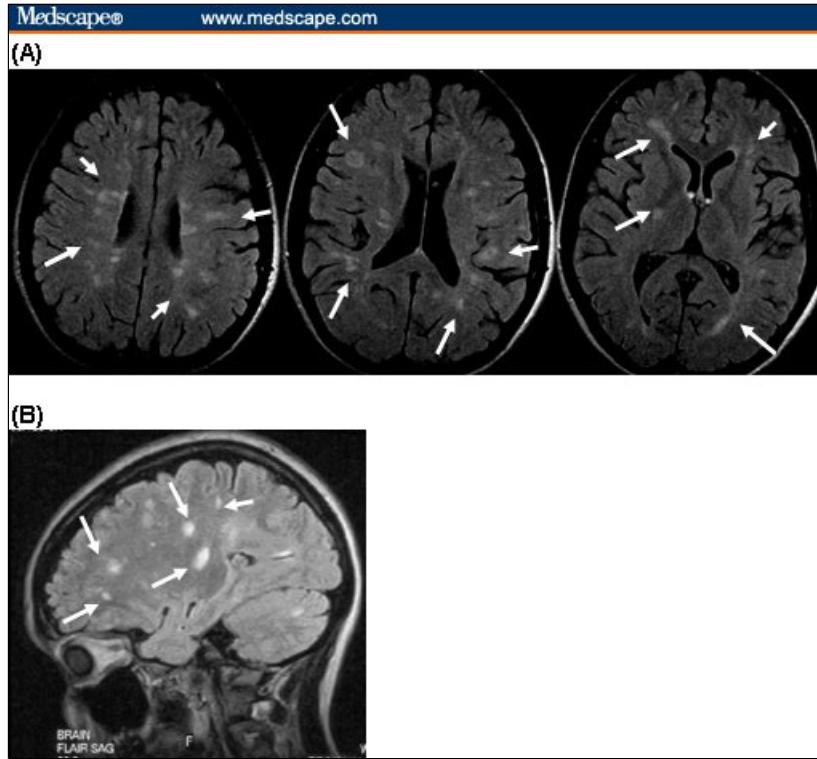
Typical changes of MS in the brain on axial and sagittal FLAIR T2 images. (A) Typical changes on axial FLAIR images. Note the periventricular ovoid lesions oriented perpendicular to the lateral ventricle, and lesions in the corpus callosum, with predilection for the frontal and posterior horns. (B) A sagittal FLAIR image, a useful sequence for identifying MS lesions.
